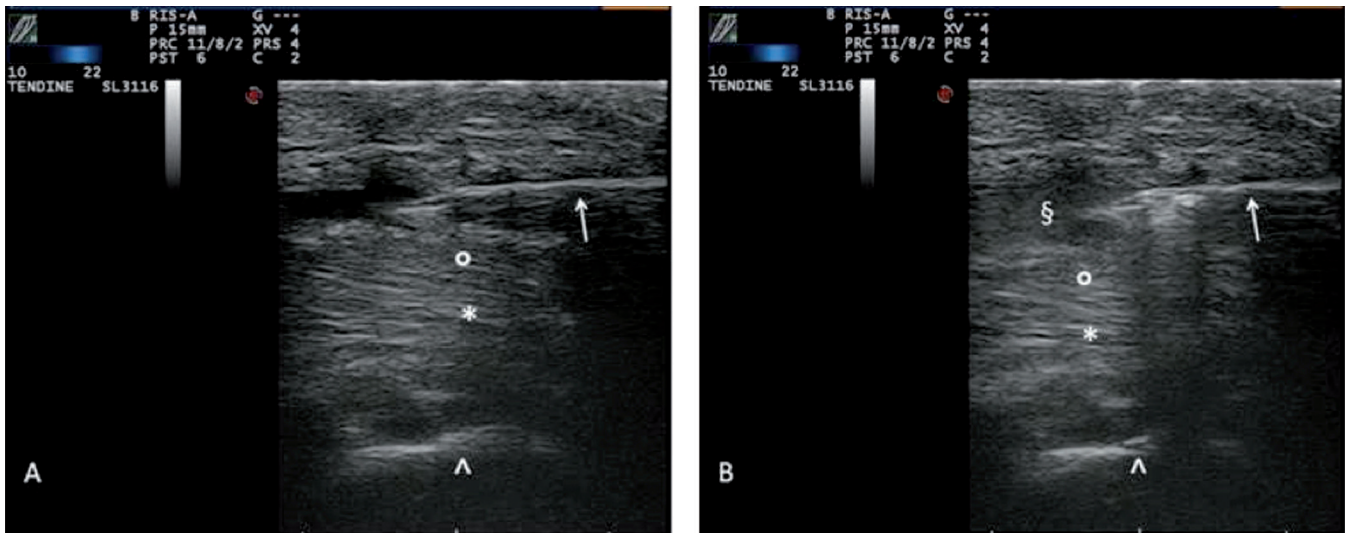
Ultrasound guided injection into the digital flexor tendon sheath; volar longitudinal scan with 22 MHz probe.
